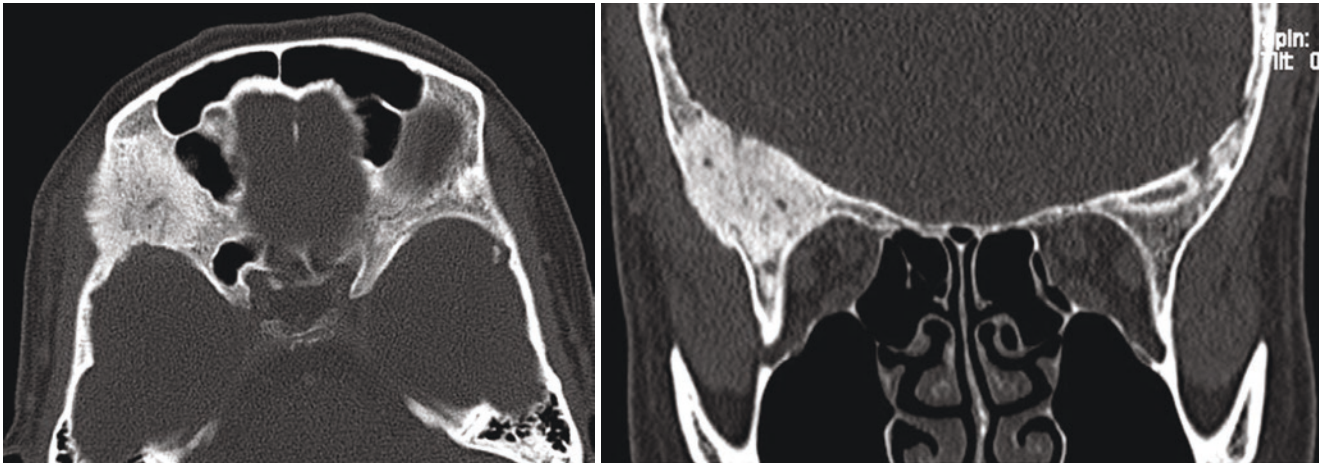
CT scan of case 2: CT bone window images show a sclerotic, expansile lesion centred on the right sphenoid wing, causing slight narrowing of the orbital apex
